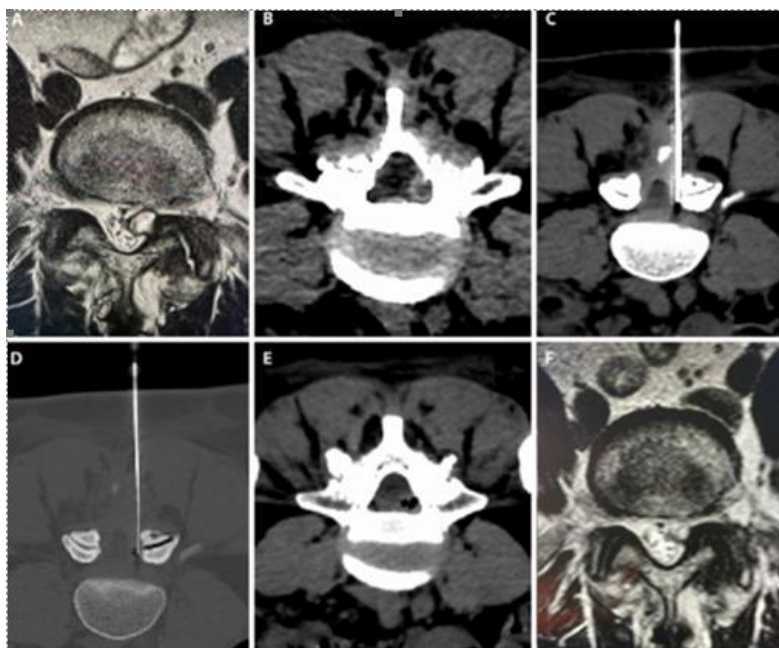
A): An axial T2W scan highlights a large synovial cyst of the left L4-L5 zygapophyseal joint; B): CT axial view of the same cyst with thickening of its walls; C-D): intraprocedural CT scan showing the correct positioning of a 22G Chiba needle inside the cyst; E): TC control after injection of the oxygen-ozone mixture; the presence of gas outside the cyst is evident. F): MRI scan highlights coarctation with a reduction in cyst volume.*
